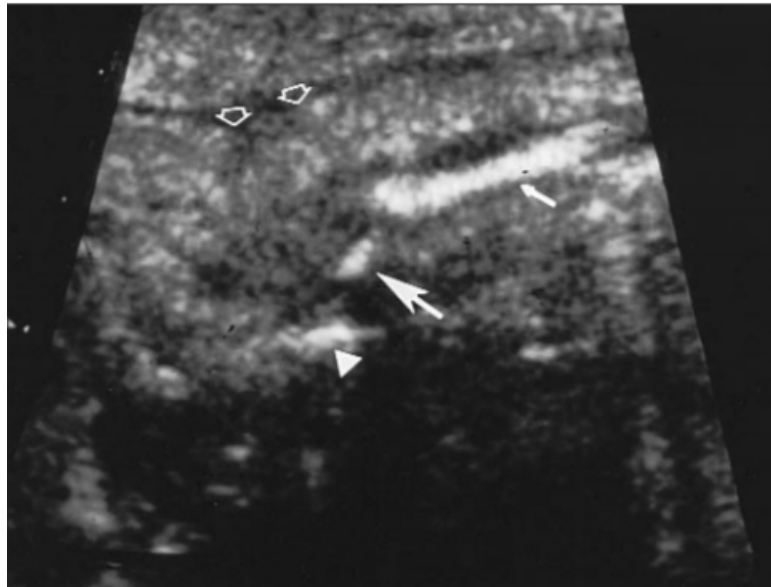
Coronal ultrasonogram of the elevated left scapula. Note the omovertebral bone (long arrow) interposed between the scapula (short arrow) and the lamina of the cervical vertebra (arrowhead). Also note the prominent soft tissue (open arrows) overlying the elevated left scapula.
